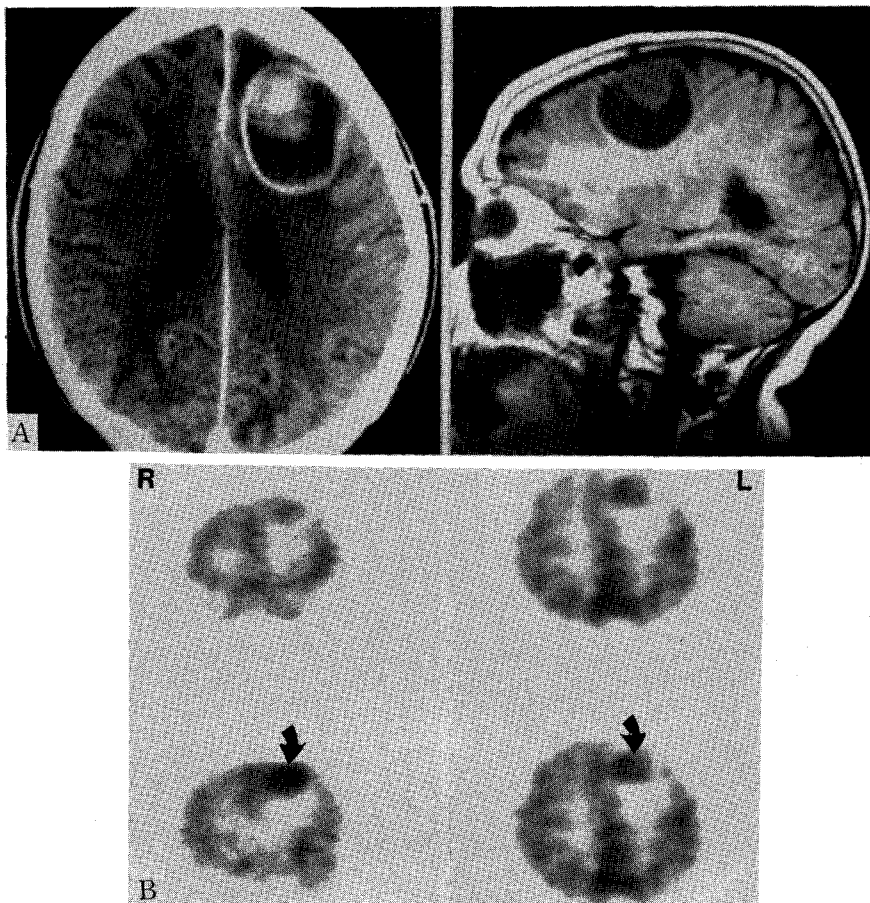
A. T1-weighted sagittal MR (upper) and transaxial CT (lower) images of the head show a lesions in the left fronto-parietal lobe with cystic and solid components.
